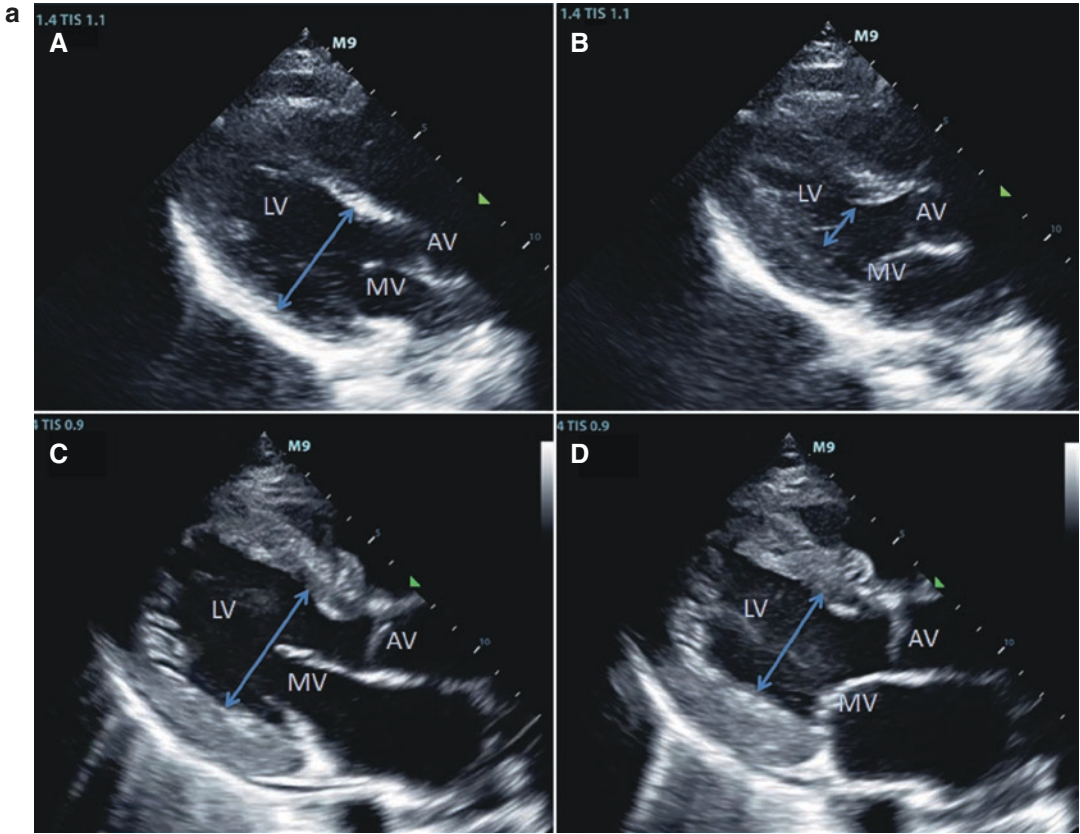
(a) Global assessment of left ventricular contractility (transthoracic echocardiogram, parasternal long axis). *A vs B*: roughly 50% decrease in LV cavity, suggests normal contractility. *C vs D*: roughly 25% decrease in LV cavity, suggests moderately depressed contractility. *LV* left ventricle, *MV* mitral valve, *AV* aortic valve, *A and C* diastole, *B and D* systole. (b) Global assessment of left
